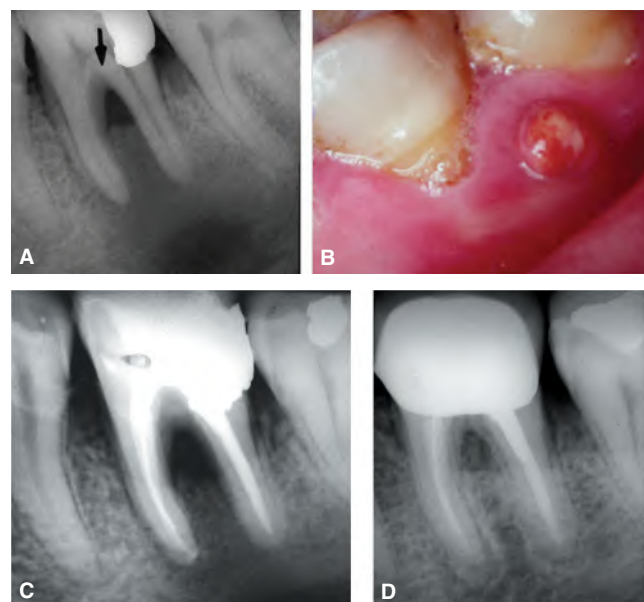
Nonsurgical endodontic treatment in a mandibular first molar of a 56-year-old male. A. Preoperative radiograph showing a large periradicular radiolucency extending to the furcation region (arrow). Pulp vitality tests were negative. B. Clinical photograph showing a sinus tract associated with the affected tooth. C. Immediate postoperative radiograph. D. 10-year follow-up radiograph showing resolution of the periradicular radiolucency. The patient was asymptomatic and the tooth restored to function.
